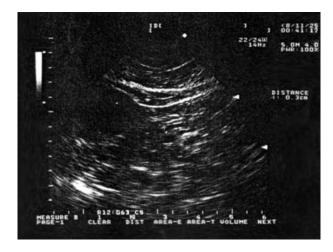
Abdominal ultrasonography imaging. Tumor size was 2.6 cm localised in the distal part of pancreatic tail.
